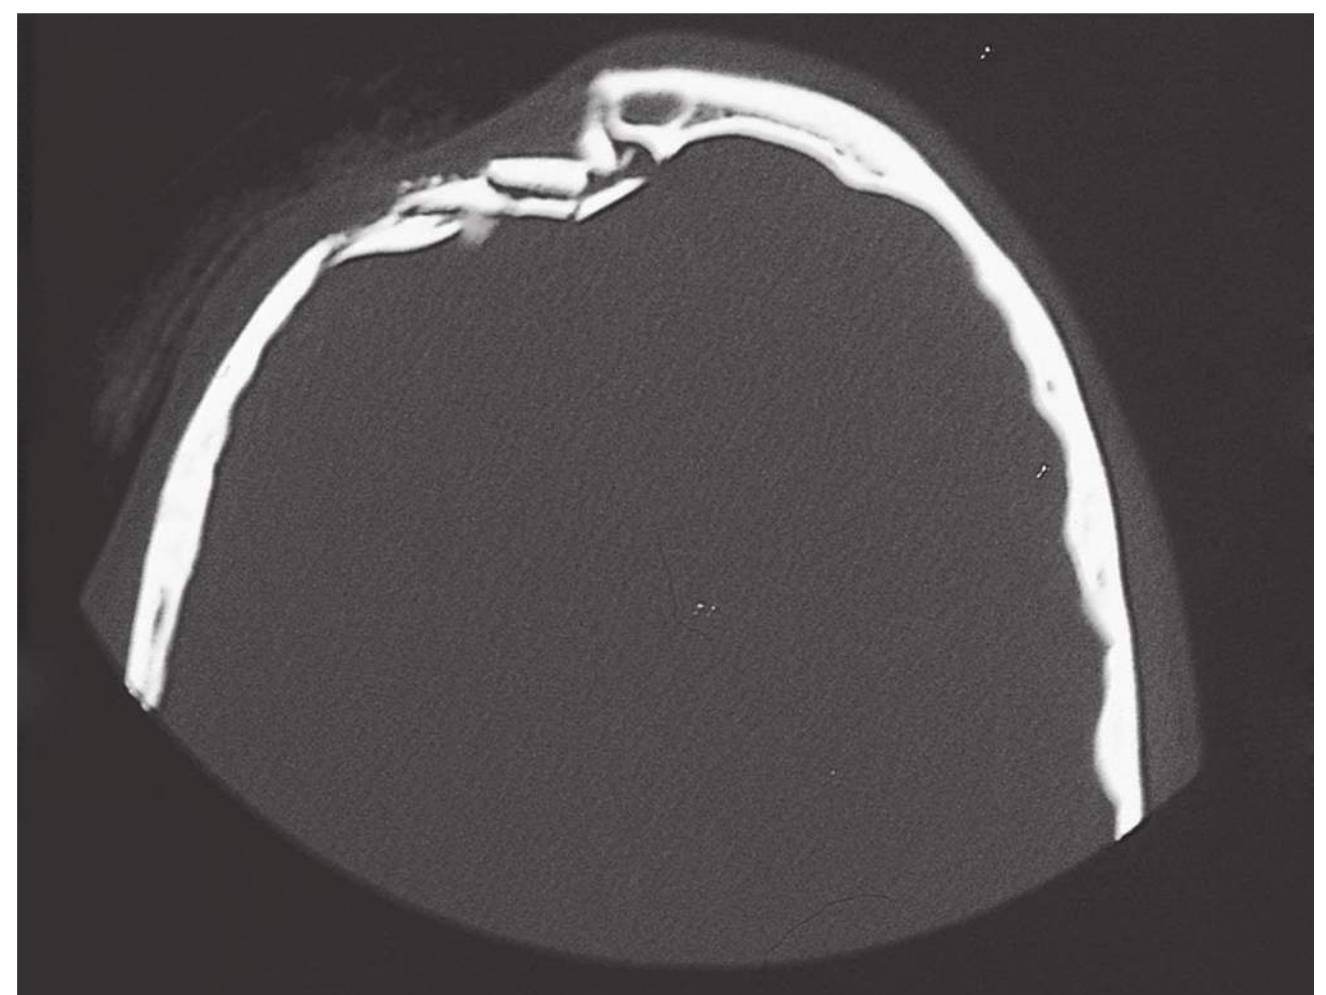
■ Depressed Skull Fracture. CT demonstrating depressed skull fracture. (Photo contributor: David W. Munter, MD.)
